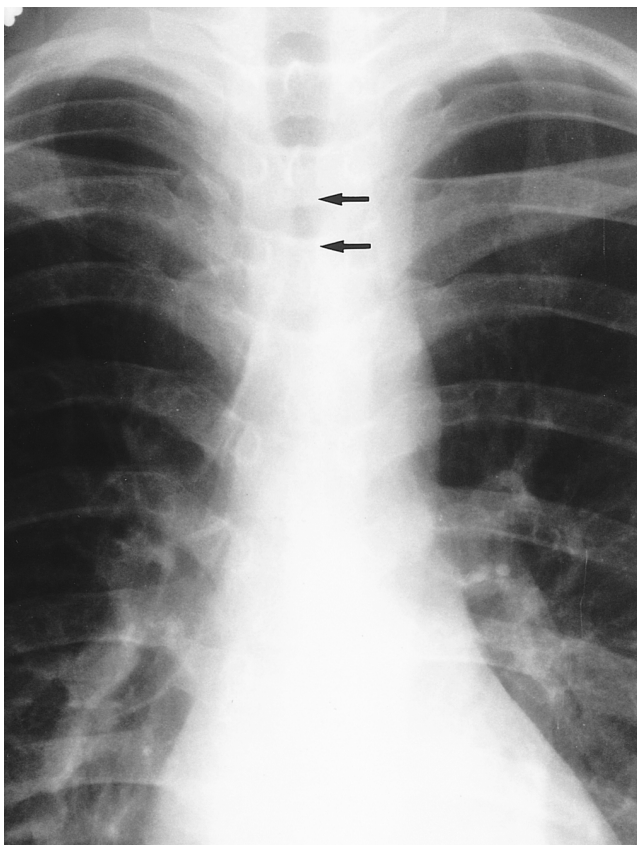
Endotracheal tuberculosis in a 26-year-old woman. Posteroanterior chest radiograph shows segmental narrowing of the trachea (arrows).
